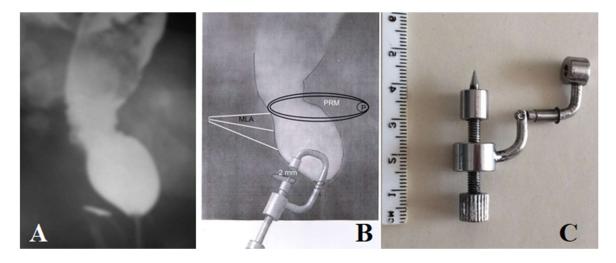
Perineal perforation scheme in patients with visible fistula using compression anastomosis. (A). Lateral radiograph of a female with a vestibular fistula. After a barium enema, a Foley catheter is inserted into the rectum. A liquid
